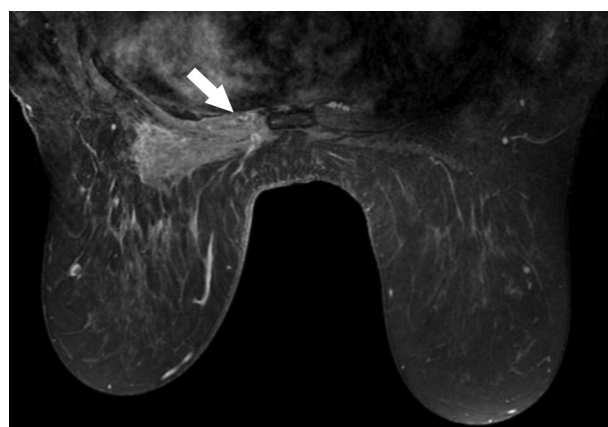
A 63-year-old woman with invasive lobular carcinoma of the left breast. T1-weighted fat-suppressed MR image in the transverse plane after administration of a gadolinium chelate demonstrates chest wall invasion as enhancement of the underlying chest wall and intercostal space (arrow).
